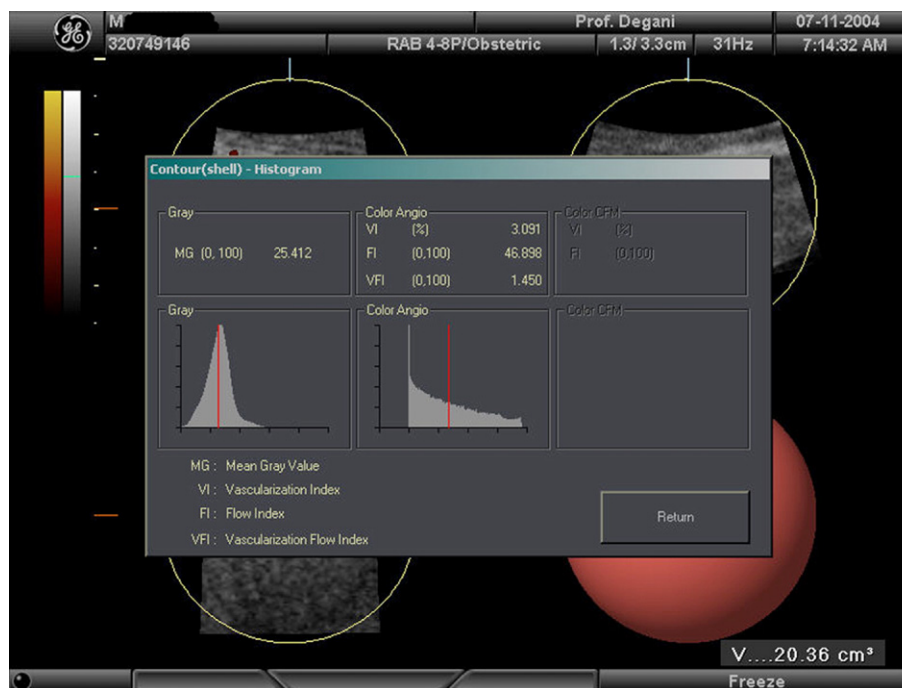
Histogram analysis of 3D power Doppler ultrasound of a sampled volume in a uterine myoma.
